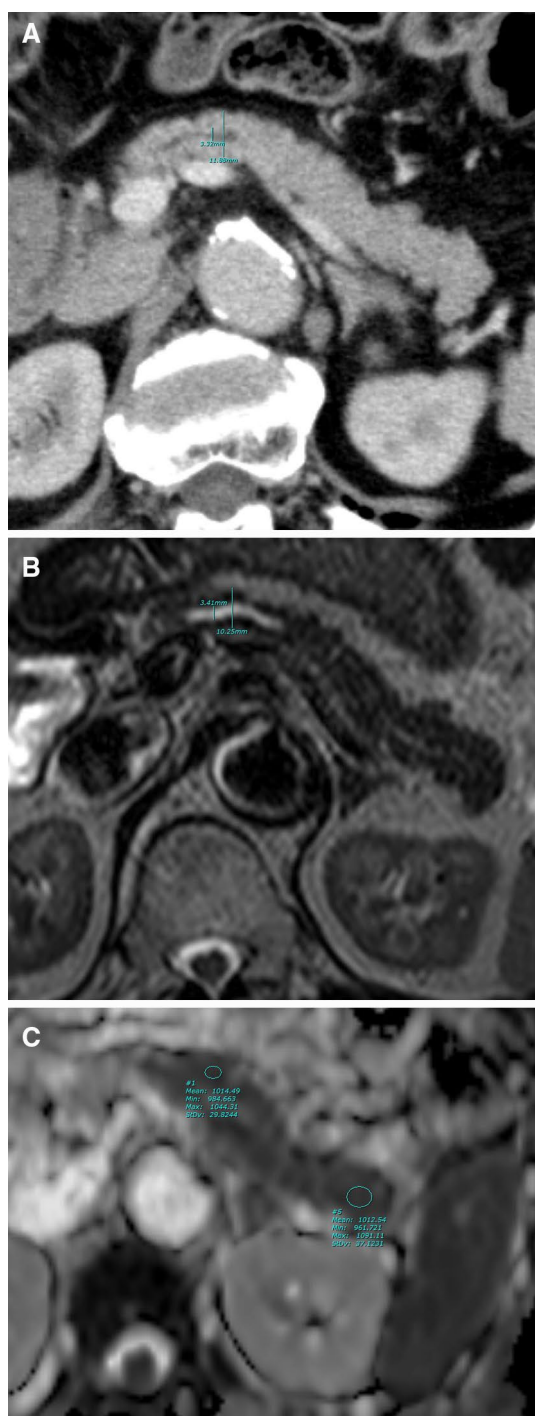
Preoperative imaging of a patient with pancreatic head adenocarcinoma without subsequent PAF. a Contrast-enhanced MDCT: the main pancreatic duct diameter (MPD) was 3.32 mm and the pancreatic parenchymal thickness (PT) was 11.88 mm. b Heavy-T2-weighted image: MPD 3.41 mm, PT 10.25 mm. c ADC measured on an ADC map in the nontumoral pancreatic parenchyma (pancreatic body and tail). The averaged value of the two ROIs was $1.013 \times 10^{-3} \text{ mm}^2/\text{s}$
